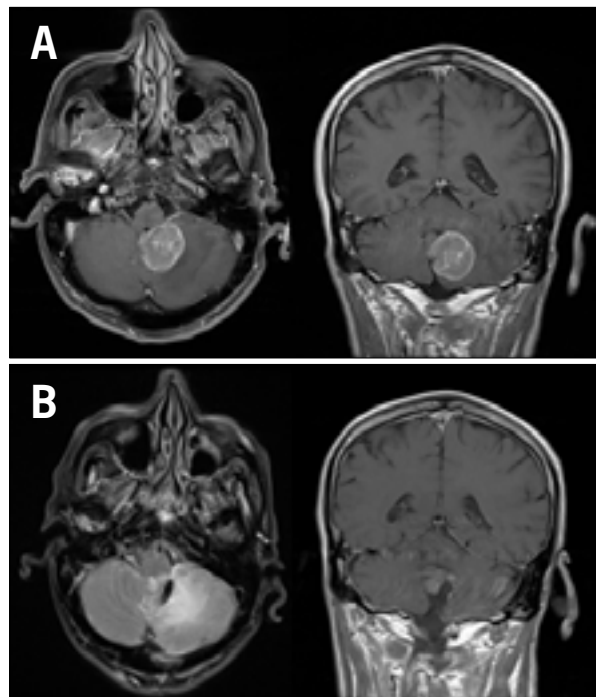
Axial and coronal magnetic resonance imaging (MRI) showing a 3.3 × 2.7 × 3.0 cm mass with heterogeneous enhancement in the left cerebellar hemisphere (A). There is also surrounding vasogenic edema, as well as a light mass effect on the medulla (B). Postoperative axial and coronal MRI show changes consistent with posterior fossa craniotomy and resection of the previously seen posterior fossa mass. A small hyperdense focus in the posterior fossa was believed to be consistent with residual tumor.
